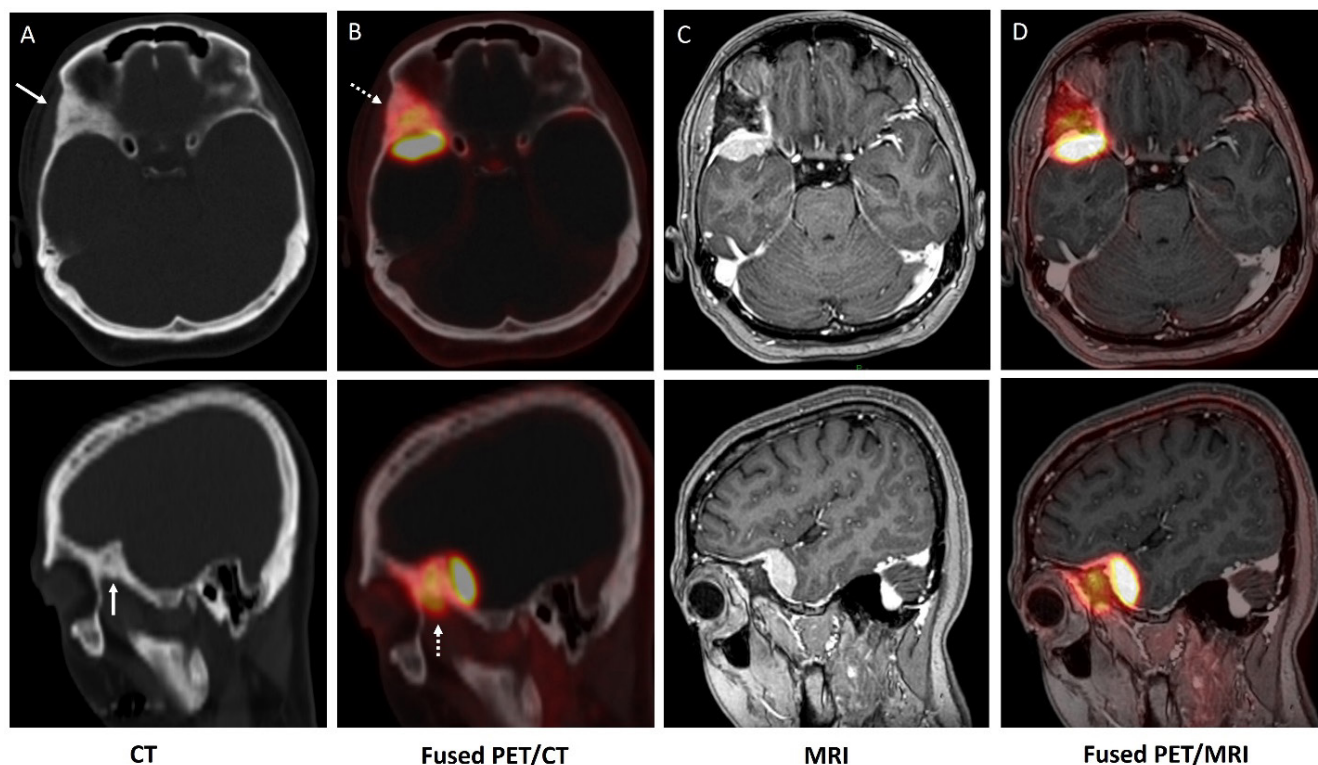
A. CT bone window showing expansile sclerosis (hyperostosis) mainly involving the right wing of the sphenoid bone (solid arrow), right lateral orbital wall, anterior clinoid process, and lateral wall of right sphenoid hemisinus with diffuse increased ^{68}Ga -DOTA TOC uptake of SUV_{max} 8.4 on fused images B (dashed arrow). C. MRI showing a well-defined lobulated dural-based mass arising from the greater wing of the sphenoid extending to the orbital apex. The lesion was better delineated on fused PET/MRI images (D). Findings are consistent with somatostatin receptor-avid meningioma with significant hyperostosis of the underlying bone, suggesting meningioma with bone infiltration.
